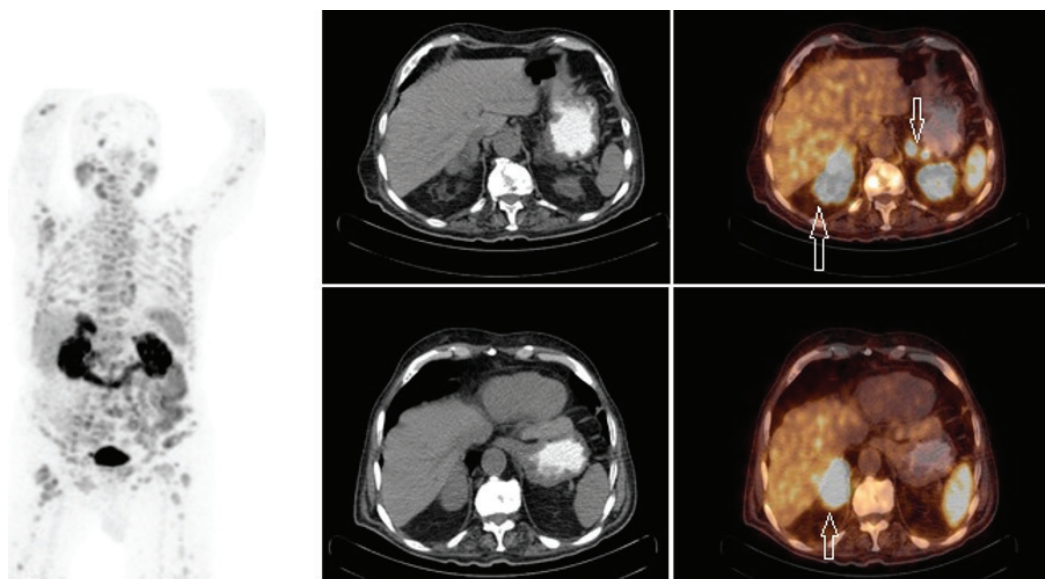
Metastases are the most common malignant lesions of adrenal gland. Adrenal metastasis can originate mostly from the lung (39%) and breast (35%) cancers (3). Even if the frequency of adrenal metastases was shown as 13% in an autopsy series, there are few publications in the literature with adrenal metastases of prostate cancer (4). ^{68}Ga PSMA PET/CT was performed in an 83-year-old patient who had prostate adenocarcinoma (Gleason's score of 4+5, PSA 809 ng/mL). Invasive prostate lesions to seminal vesicles, bilateral adrenal masses with the largest diameter of 61x33 mm (SUV_{max} : 26.2) (arrow), abdominopelvic lymph nodes, and widespread sclerotic skeletal metastases with intense PSMA expression were detected. Androgen deprivation therapy and chemotherapy were started and he has been for follow-up.
